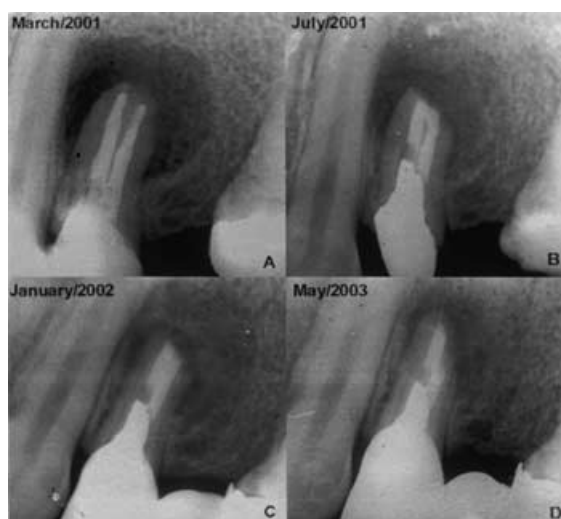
(A) Periapical film after root canal retreatment showing a large periapical lesion; (B) radiographic evidence of healing of the periapical reaction 2 months after endodontic surgery; (C) radiographic review 8 months postsurgery; and (D) radiographic review 24 months postsurgery.
